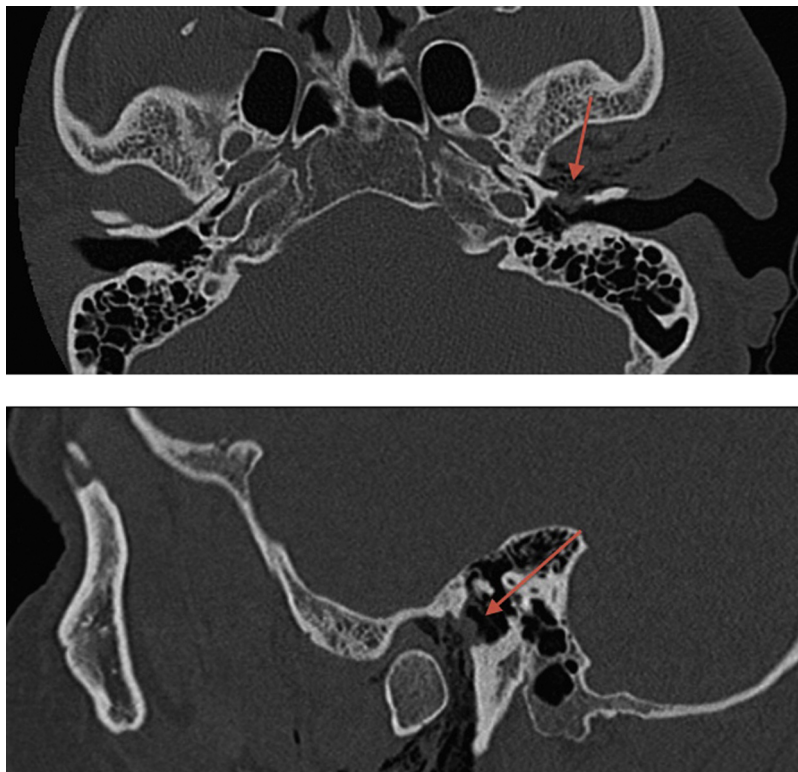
CT axial and sagittal view demonstrating the herniation of soft tissue (arrow) through the patent foramen of Huschke into the external auditory canal.
